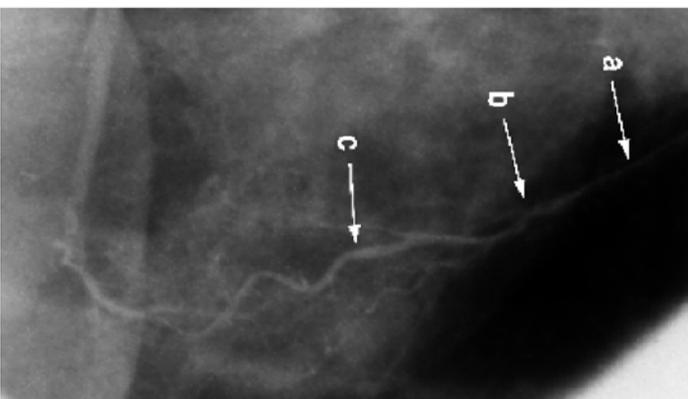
Supraclavicular ultrasonography of a string sign LIMA graft at angiography.
